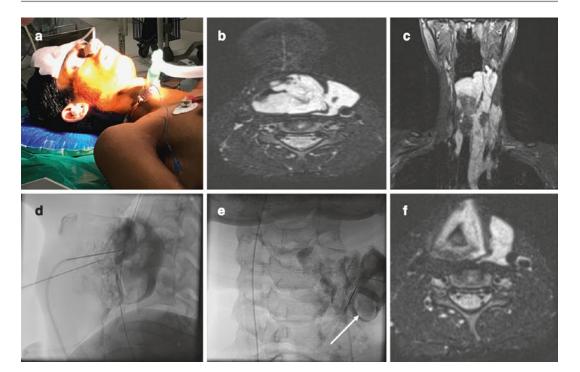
A 19-year-old male presenting with severe dyspnea on lying down and inability to sleep supine. (a) Intraoperative clinical photograph showing patient intubate via tracheostomy to provide a patent airway. Difficult tracheostomy as venous malformation is involving larynx and tracheal cartilages and continuing along the anterolateral aspect of the neck down up to the upper mediastinum. (b) Preoperative magnetic resonance imaging axial section showing hyperintense malformation involving the laryngeal cartilage and occupying the airway leading to symptoms (c) Preoperative magnetic resonance imaging
